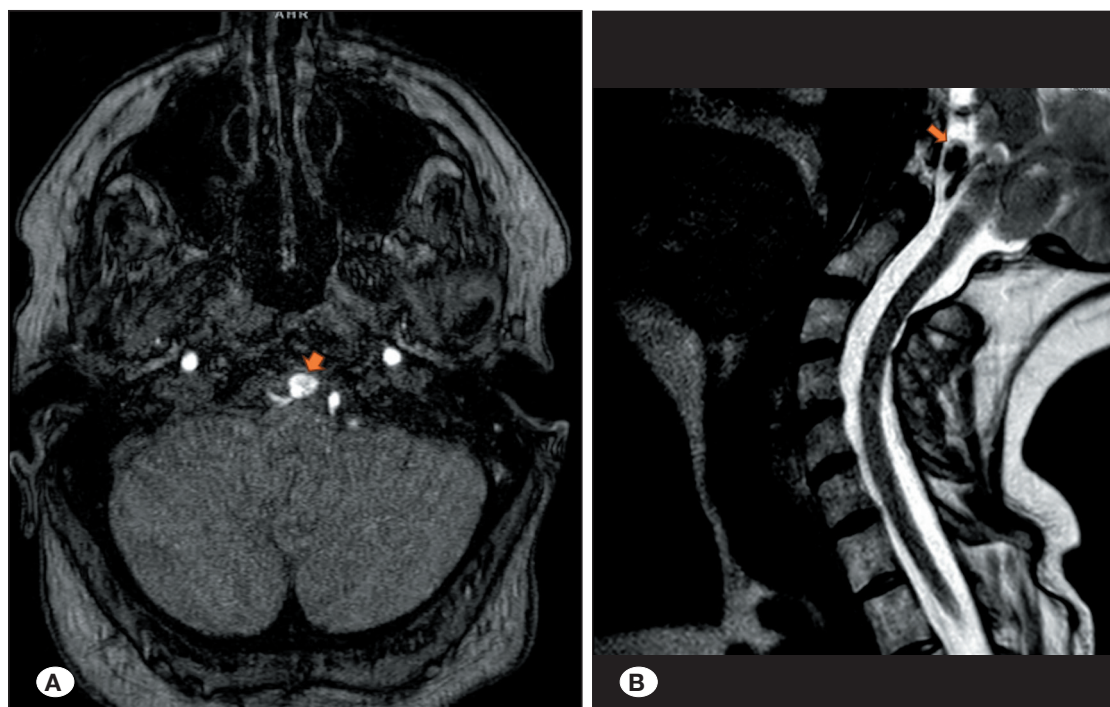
Magnetic Resonance Imaging (MRI) head and neck. A) MR Angiogram axial view reveals a 9 x 5 mm aneurysm in the right V4 segment of the vertebral artery (orange arrow). B) T2-Weighted MRI cervical spine sagittal view redemonstrating said aneurysm (orange arrow).
